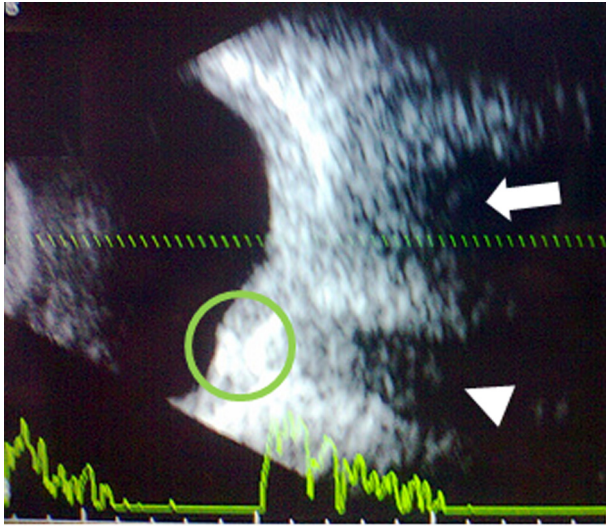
Ultrasound B Scan image depicting the true optic nerve shadow (arrow) along with the pseudo optic nerve shadow (arrow head). The encircled area represents the possible location of the foreign body.
